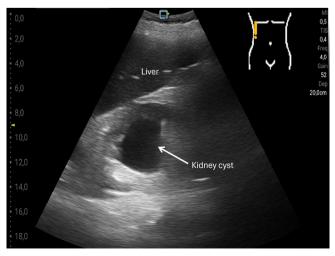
Sonographic image of a right-sided renal cyst visualized with the Youkey Q7
